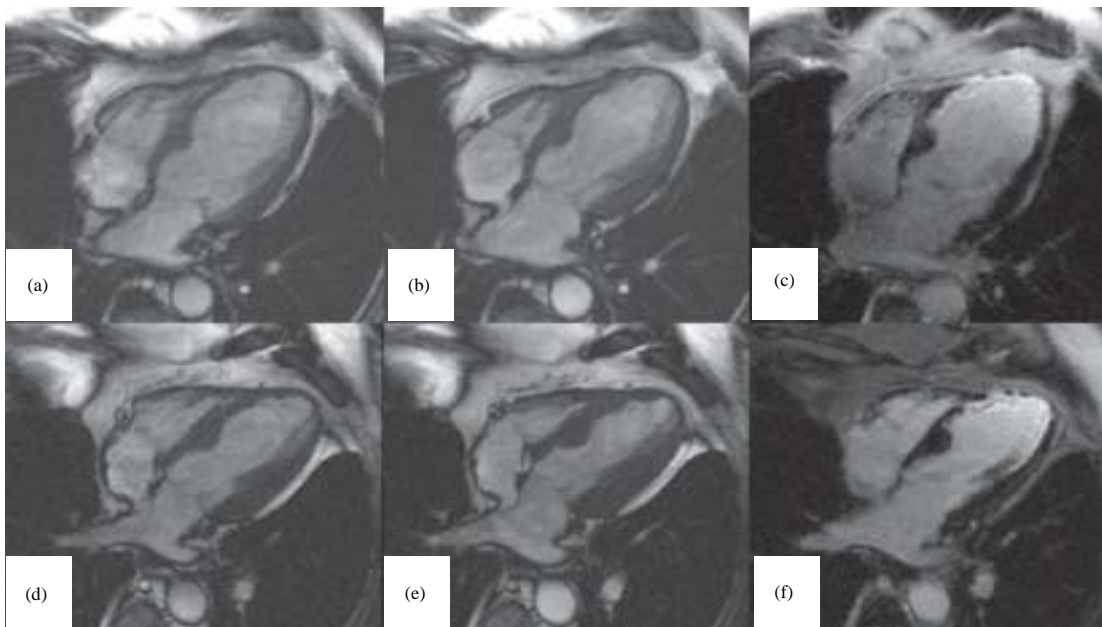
(a-f): MRI of a case before (top line) and after (bottom line) 3-fold CABG. (a) SSFP cine images in end diastole and (b) End systole reveal the severely impaired global LV function before surgery (EF 30%), (c) Ce-turbo fast, low angle shot (FLASH) image shows broad sub-endocardial late enhancement (bright signal) in the apical septum, thin LE in the lateral wall and transmural LE in the apex meaning chronic scar. The LV function after surgery, (d-e) No improvement in the apical septum and the apex, whereas the complete lateral wall improved and became normo-kinetic and (f) No changes in scar extent<sup>36</sup>
